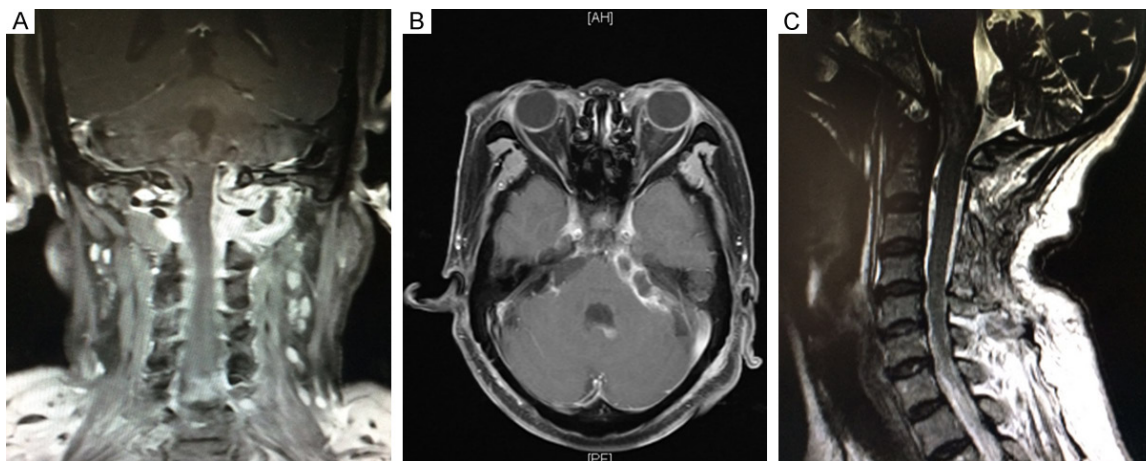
Postoperative magnetic resonance imaging demonstrated extended endocranium lesions of middle and posterior fossa, as well as multifocal epidural abscesses. A: Coronal view; B: Horizontal view; C: Cervical sagittal view showed absence of epidural spinal abscess.
